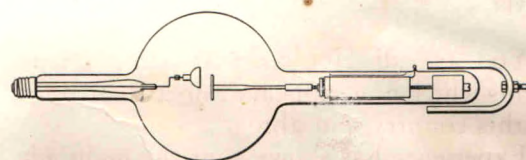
Hot-cathode x-ray tube with rotating target.
